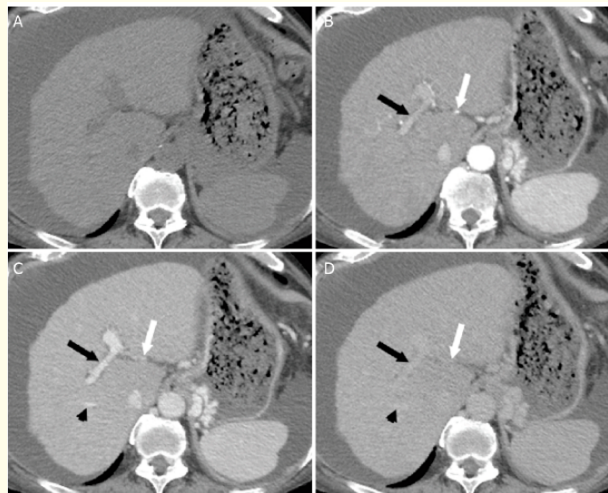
Shows dynamic imaging for evaluation for hepatocellular carcinoma. Axial CT images demonstrating the pre-contrast (A), hepatic arterial (B), portal venous (C), and delayed (D) post-contrast imaging phases [3].
